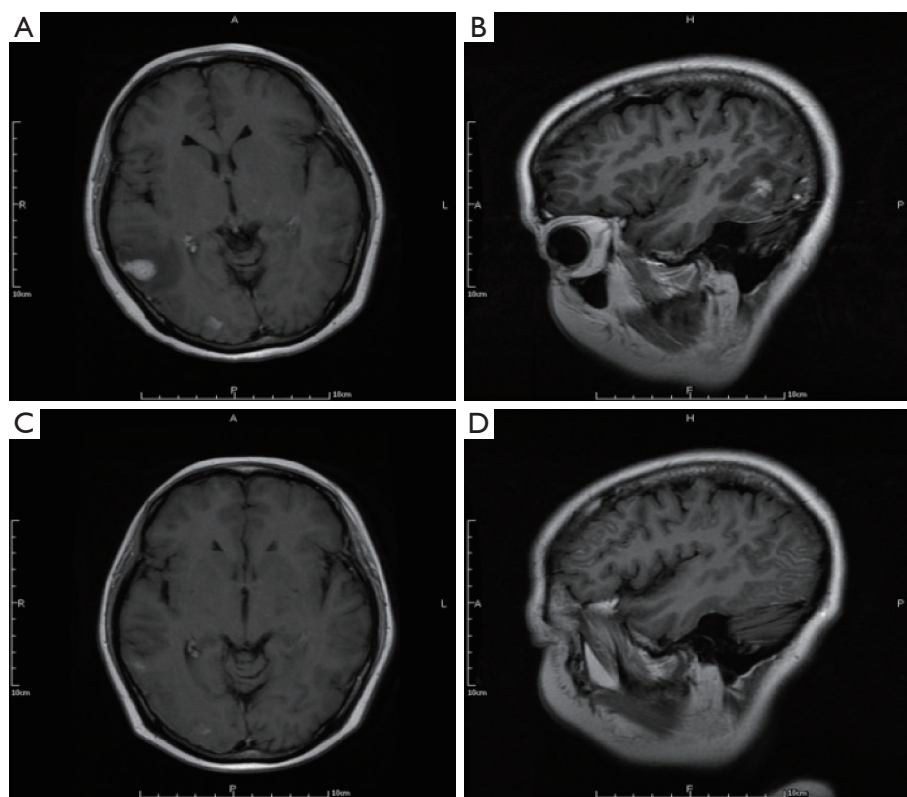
The brain MRI of a lung adenocarcinoma patient with brain metastasis before (A,B) and after (C,D) 2 cycles of bevacizumab.
